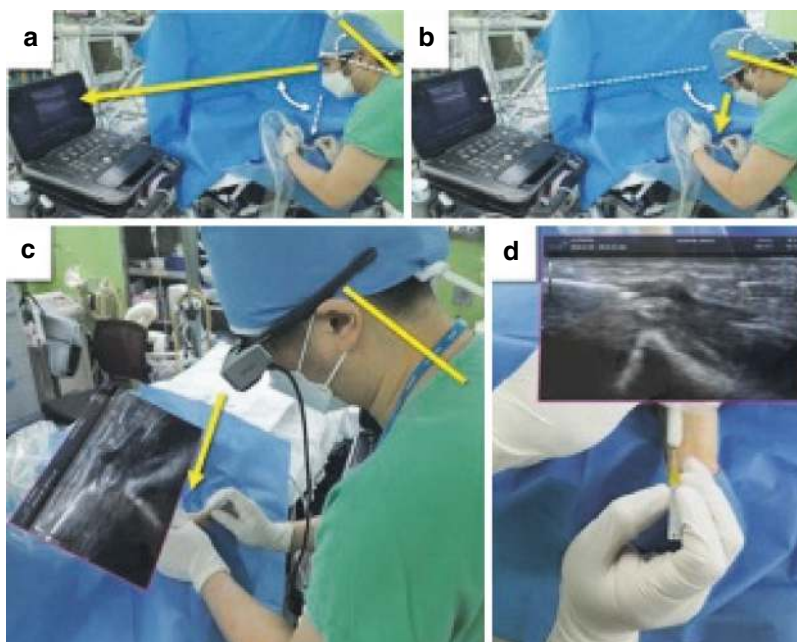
Ultrasound-guided radial artery cannulation in the control group (a, b) and the smart glasses group (c, d). The thick yellow lines indicate the operator's cervical spine and gaze, and the thin white lines and arrows indicate the range of motion. (a) The operator is looking at the ultrasound screen to find the radial artery. (b) The operator moved his
